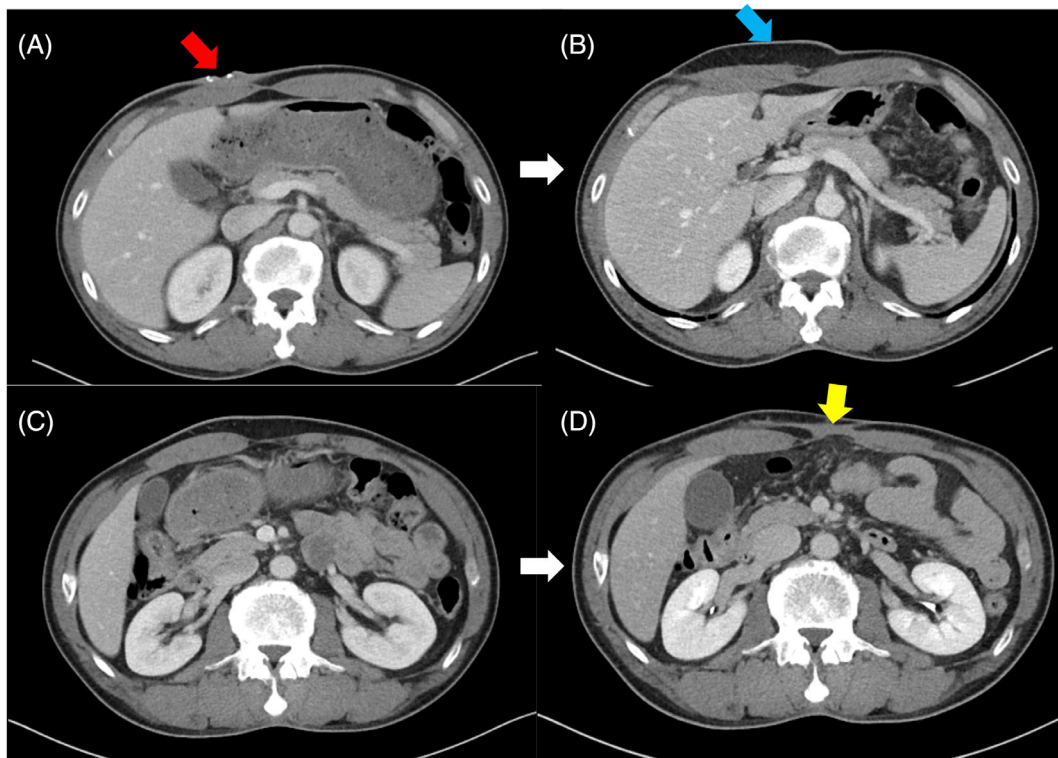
A, On the computed tomography (CT) scan, we noticed 4 cm sized skin thickening and ulceration at his right upper quadrant abdominal wall. (Red arrow) The inflammatory lesion adjacent to the skin thickening area was mainly located at the subcutaneous layer connected with the right rectus muscle. B, This is a CT scan taken postoperatively for 4 months. We can see a well-maintained flap (blue arrow). C, Preoperative CT scan. D, Postoperative CT scan revealed well maintained implanted tensor fascia lata allograft (yellow arrow) connected to the right rectus muscle
